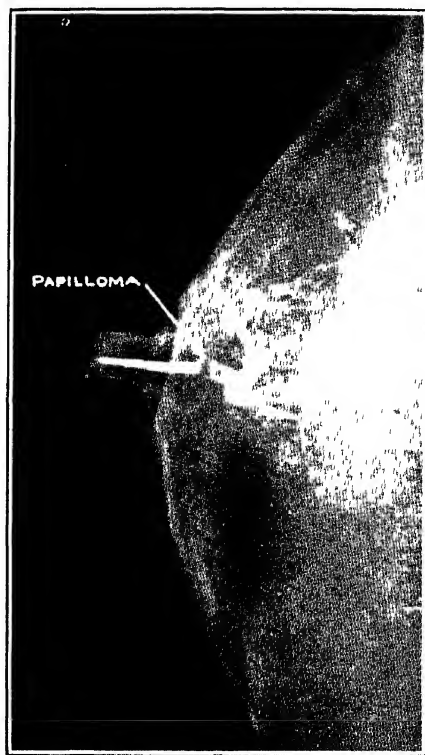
Retouched mammogram showing the "filling defect" caused by a non-palpable, bleeding, intraductal papilloma. (Am J Roentgenol, March, 1938.)
